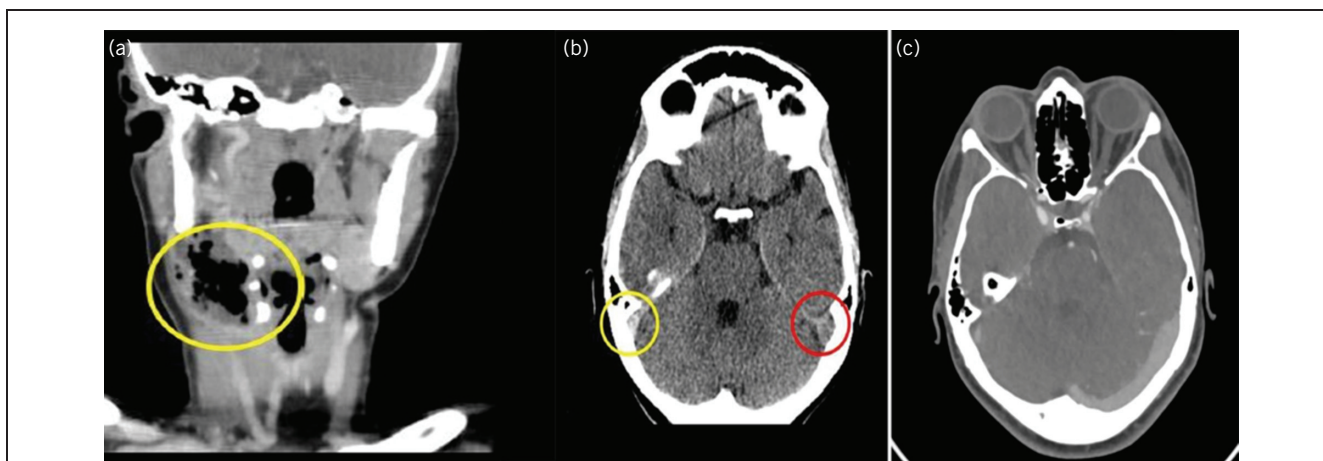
(A) Contrast-enhanced computed tomography of the abscess with jugular vein thrombosis. (B) The vessel thrombosis at the level of the sigmoid sinus. (C) One-year of follow-up, showing the full recovery of the patient.
